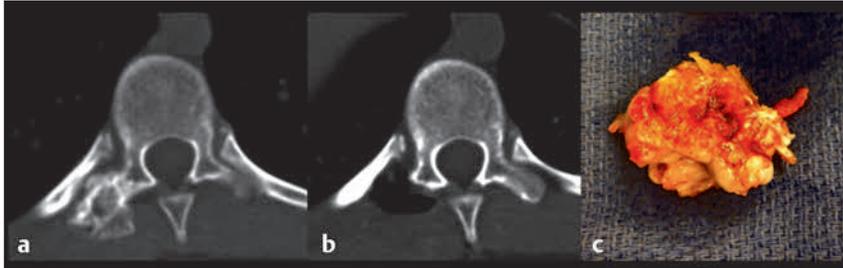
This 15-year-old boy presented with back pain. (a) Axial noncontrast computed tomography demonstrates a lesion originating from the T10 transverse process. (b) The lesion was removed en bloc. (c) Osteochondroma.
